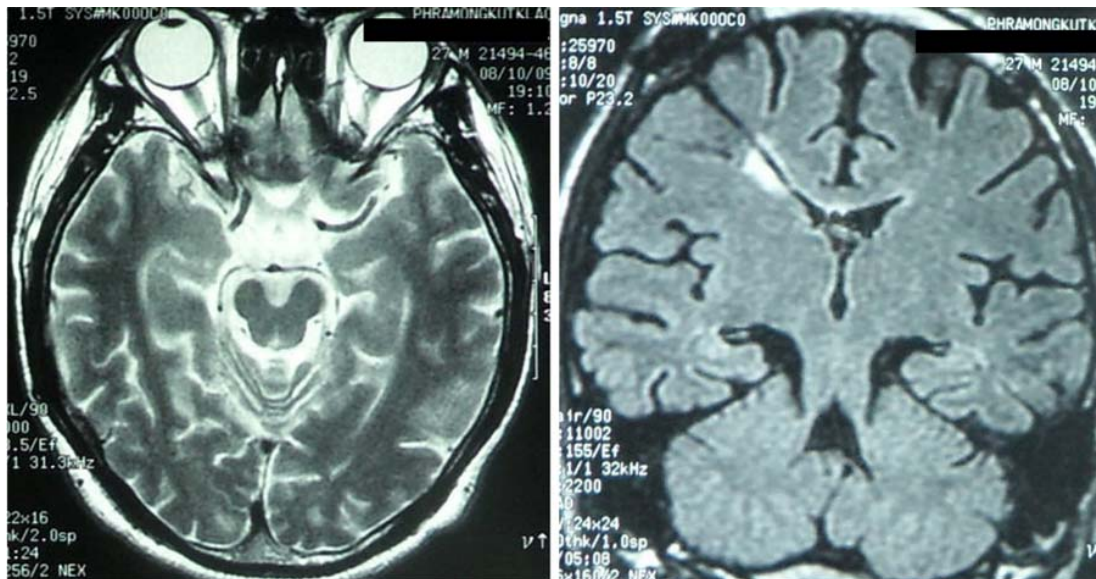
MRI brain showed no evidence of hydrocephalus. There was a small hyper-signal intensity lesion around the VP shunt's tube over the right frontal area
